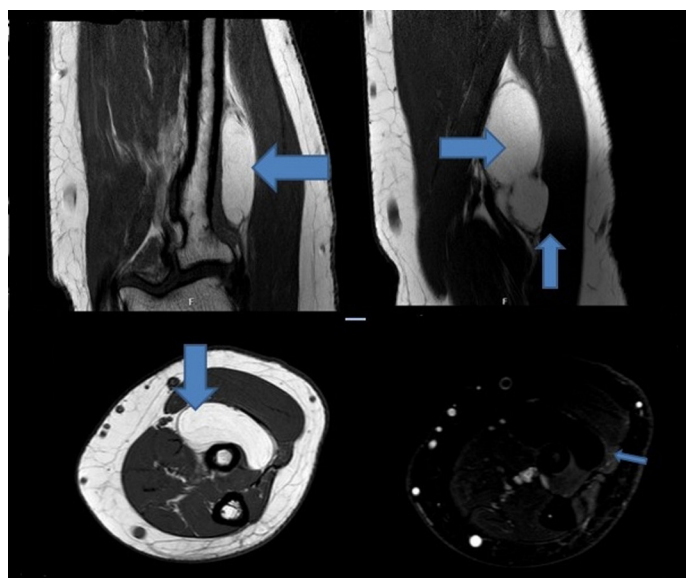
Magnetic resonance images of the mass in the forearm (Blue arrows)
